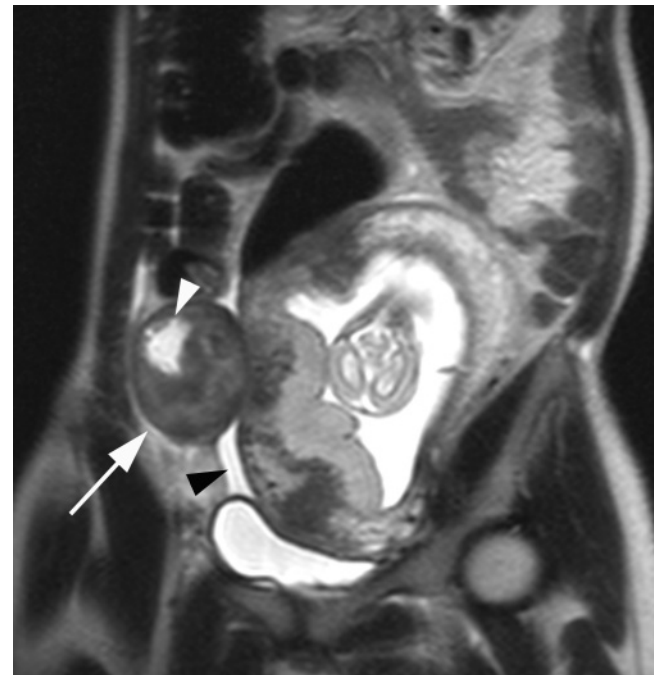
Torsed subserosal fibroid in a pregnant patient. Coronal T2-weighted SS-ETSE image in a patient with severe right lower quadrant pain shows a subserosal fibroid (arrow) with evidence of degeneration (white arrowhead) and a small amount of adjacent fluid (black arrowhead). At surgery, a pedunculated fibroid was found to be twisted 270°.
